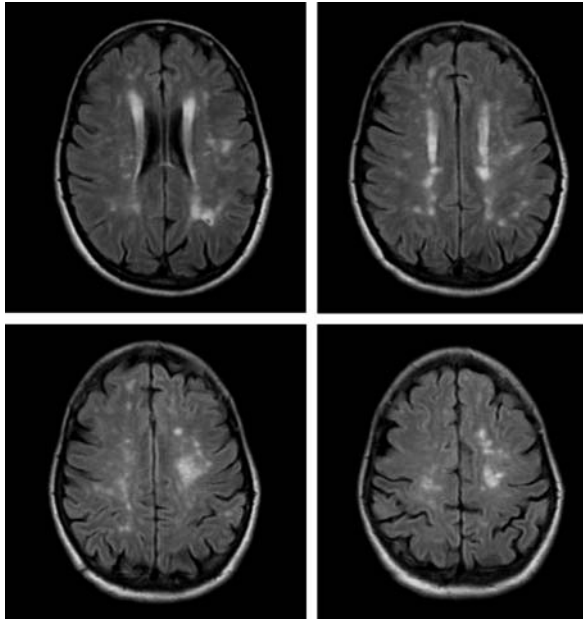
Axial FLAIR sequence displays sample images of CADASIL MRI pattern of conventional MRI in a 32 y.o. patient.
